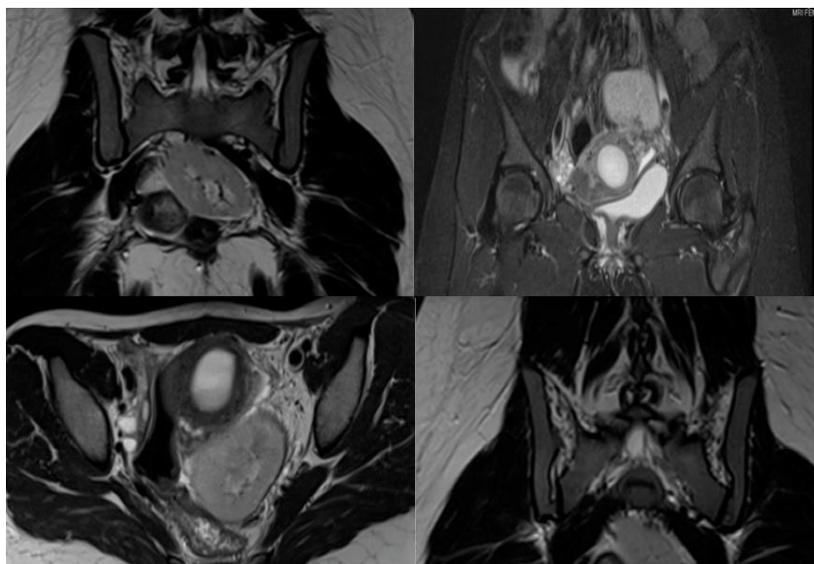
CT scan showing bulky bicornuate Uterus with fluid accumulated inside the endometrial cavity and solitary pelvic kidney.
